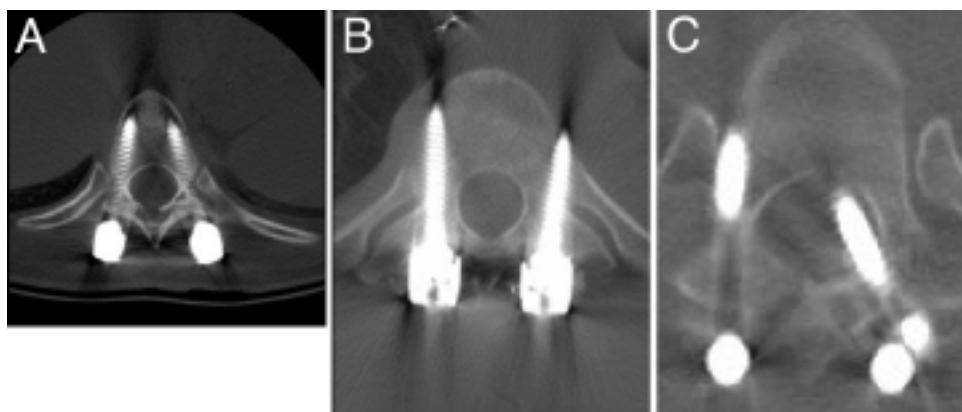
A: Postoperative CT scan demonstrating placement of PSs fully within the pedicle walls. B: Postoperative CT scan demonstrating placement of PSs with lateral wall perforation. C: Postoperative CT scan demonstrating placement of PSs with medial wall perforation.
